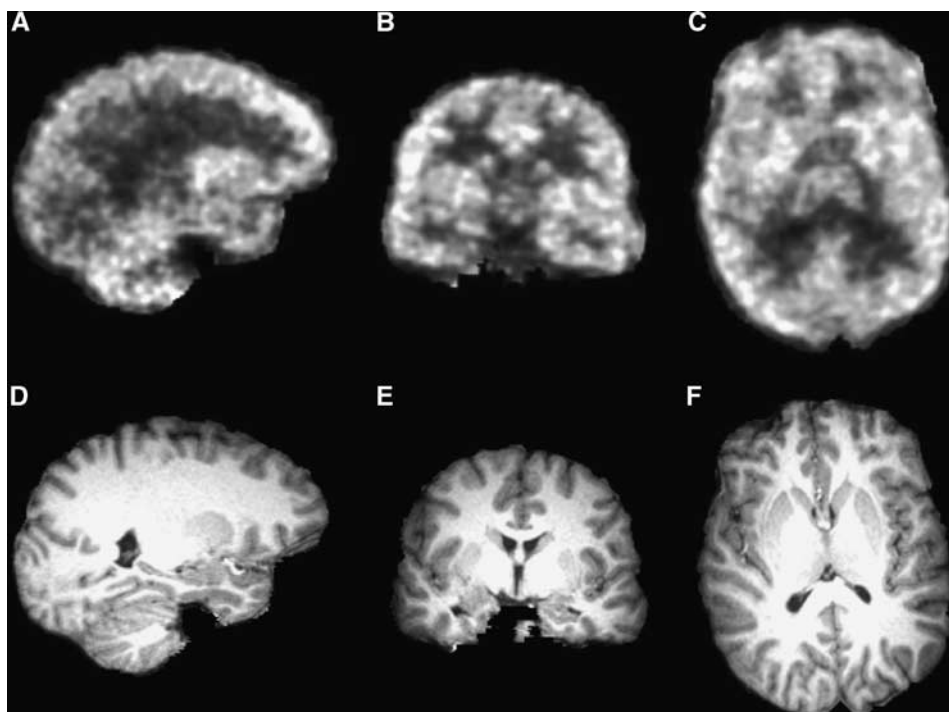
Representative positron emission tomography (PET) images summed 40 to 60 minutes after injection of 680 MBq of [¹¹C]OMAR (A–C) and subject's T1-weighted magnetic resonance (MR) images (D–F) shown in the same space as reconstructed PET data. Sagittal slices shown in A and D, coronal slices in B and E, and axial slices in C and F.
